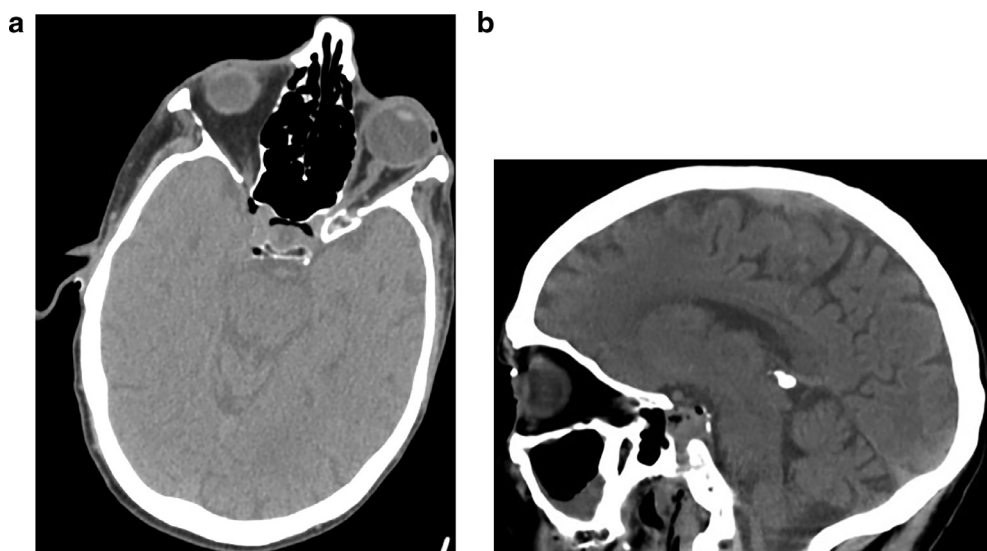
(a) CT head scan (transverse plane) showing the presence of gas within the cavernous sinus. (b) CT head scan (sagittal plane) showing the presence of gas within the cavernous sinus.
